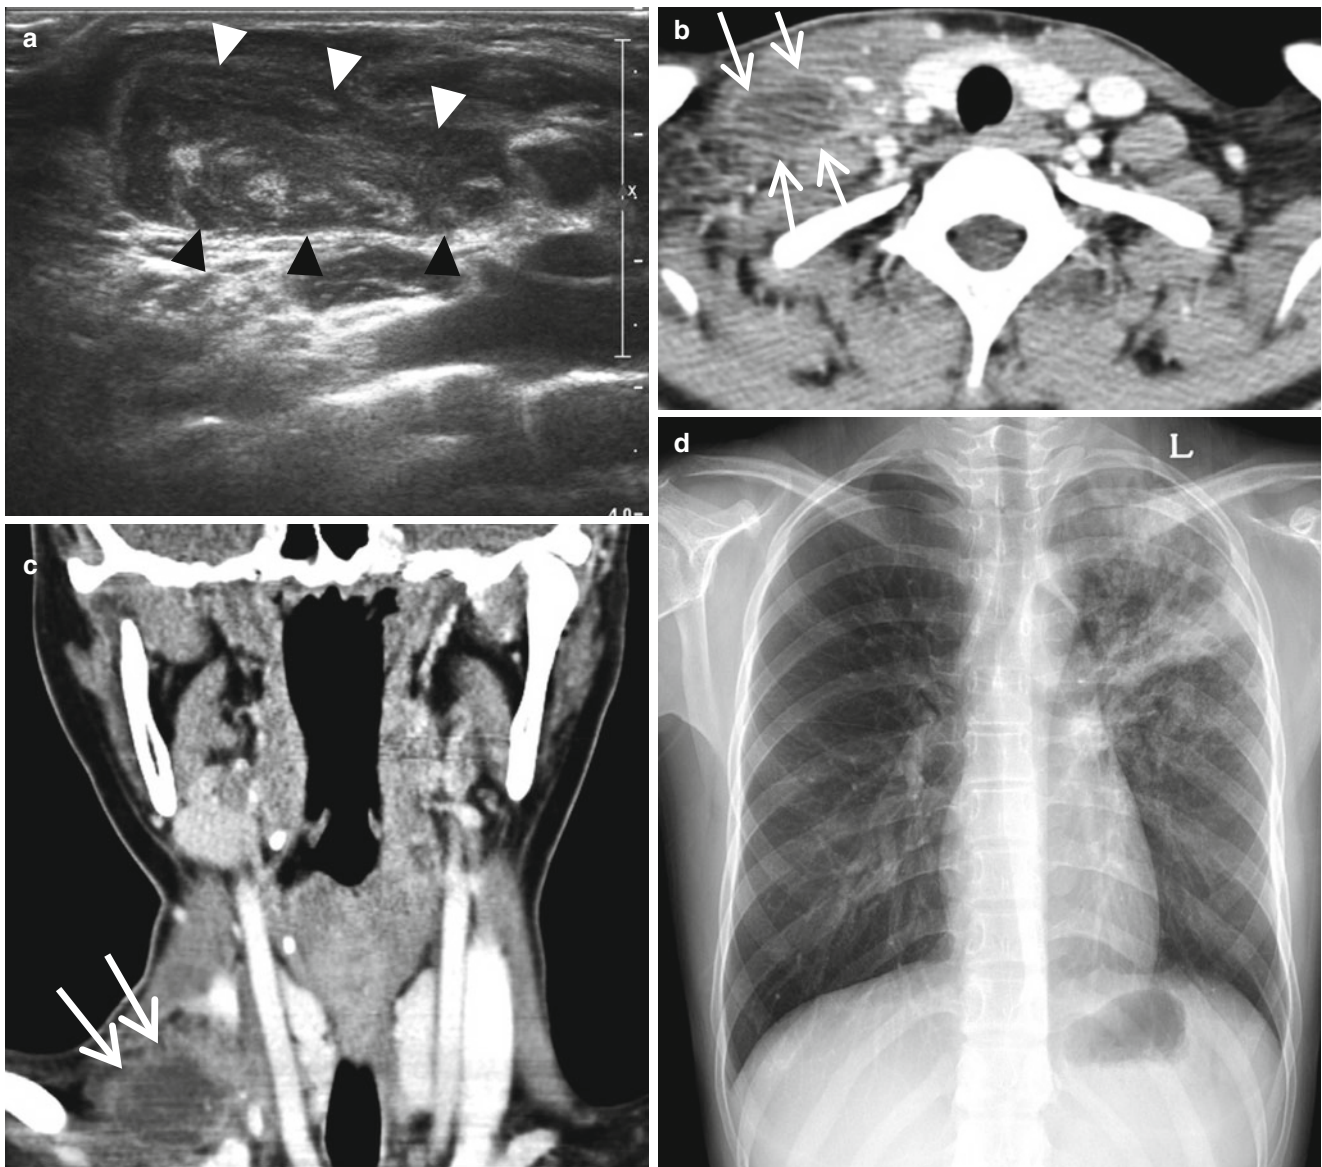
Tuberculous cervical lymphadenitis. (a) Ultrasound shows an ill-defined hypoechoic lesion (*arrowheads*) in the right neck with internal hyperechoic foci. (b, c) Postcontrast axial (b) and coronal (c) CT images show a rim-enhancing abscess cavity (*arrows* in b and c)
